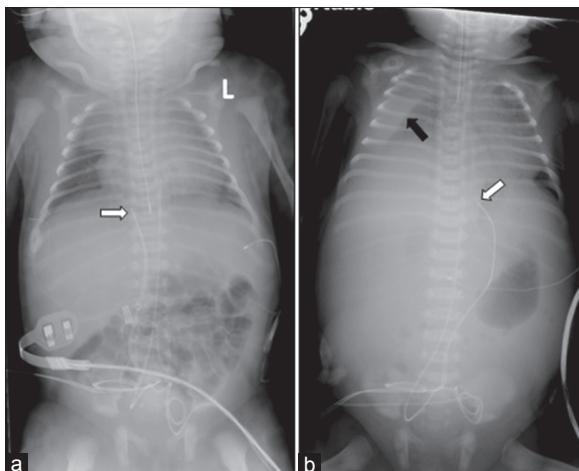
(a) Chest and abdominal AP radiographs at day 1 after UVC placement with tip at T9 near midline. (b) Radiographs with large right pleural effusion, ascites, and the UVC displaced to the left of the midline. White arrows point to UVC tip. Black arrow points to pleural effusion
